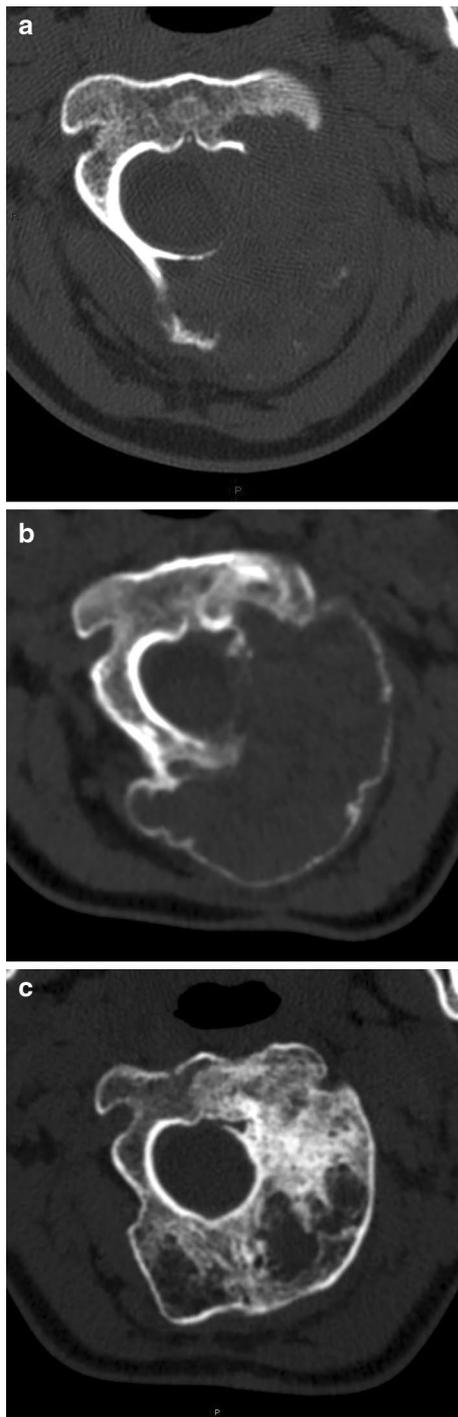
a Trocar biopsy confirmed C2 ABC in a 14-year-old girl. Lytic change of the whole left hemivertebra. Pain and clinical instability. No neurological symptom. b SEA with closure of the vertebral artery was not sufficient to stop tumor growth. Protocol of centrifugate bone marrow (CBM) was started. c After three CBM injections, reconstruction is achieved. Ossification and tumor mass shrinking. CT scan control 3 years after the diagnosis
